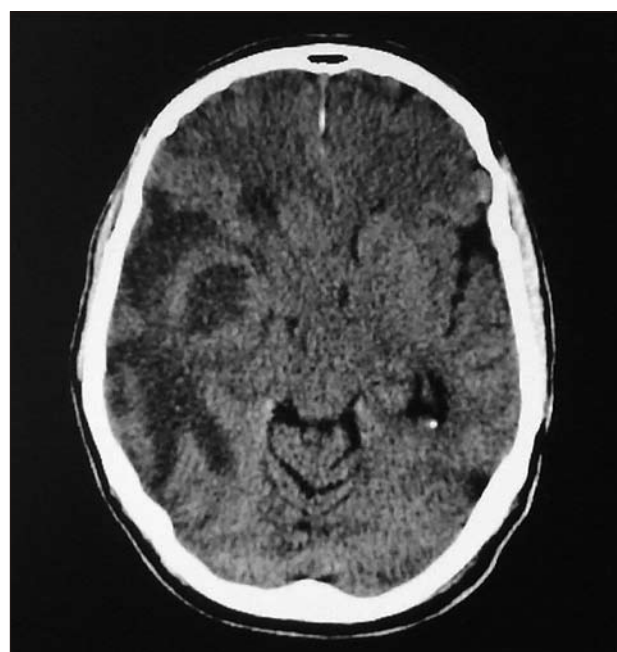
Computed tomography scan demonstrating a peripherally enhancing lesion with surrounding vasogenic oedema in the right temporal area.
